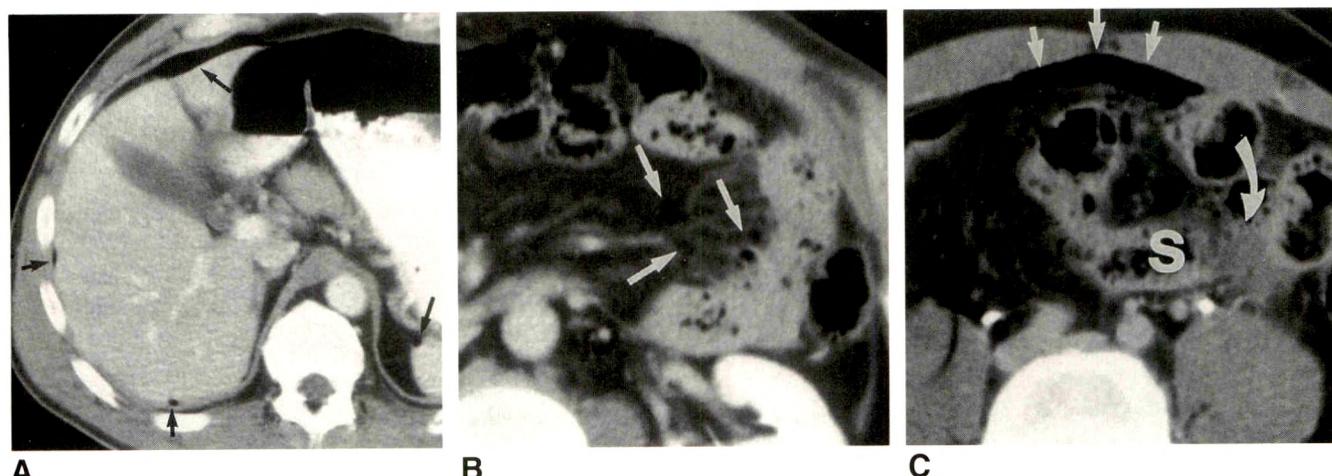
Traumatic perforation of jejunum. Contrast-enhanced CT scan obtained with wide window settings shows subtle pneumoperitoneum (arrows).
